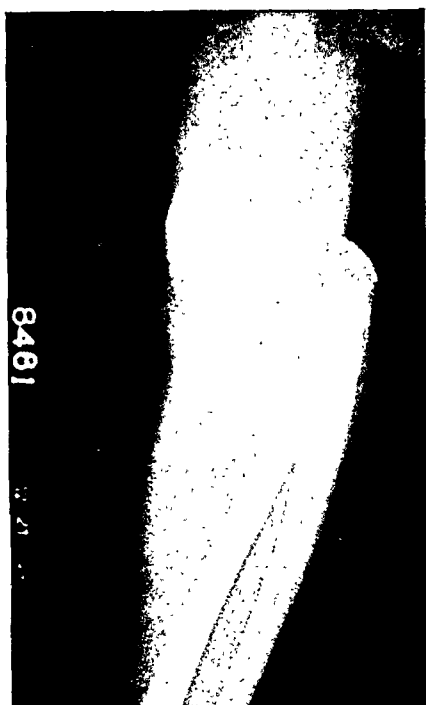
Anteroposterior and lateral roentgenograms showing posterior, lateral and upward dislocation at elbow with intra-articular interposition of epitrochlea.
